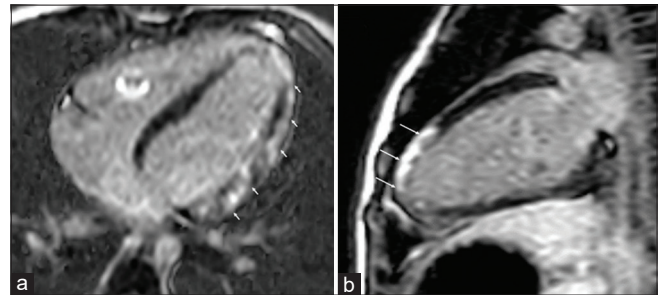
Cardiac MRI (short-axis view) with the phase inversion recovery sequence in short axis view of an 18-year-old with DMD and severe cardiomyopathy (a–d). The images demonstrate extensive late gadolinium enhancement (white arrows) in a nonischemic pattern (subepicardial enhancement in the basal to apical lateral and inferior segments) and mid-wall enhancement in the basal inferoseptal segment and mid to apical septal segments. There is also partial enhancement of both papillary muscles. DMD: Duchenne muscular dystrophy, MRI: magnetic resonance imaging
